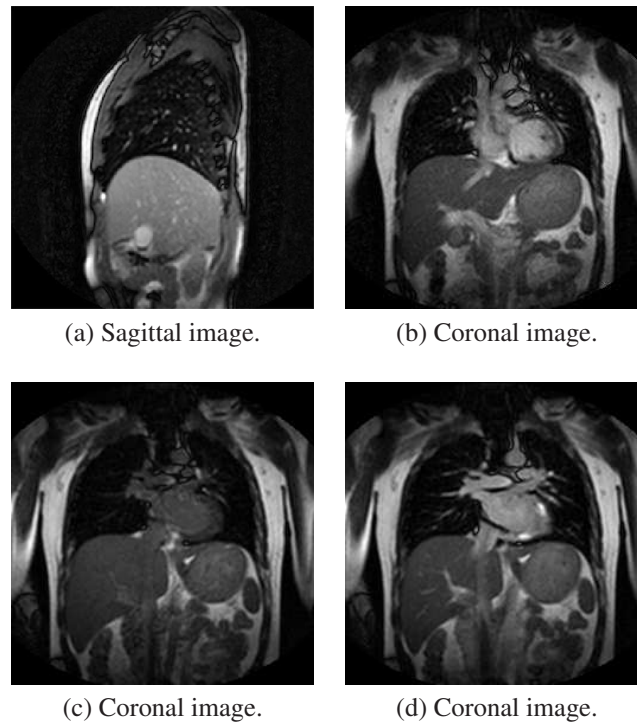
Samples of MR images. (a) shows a sagittal image. (b) shows the ascending aorta. (c) and (d) show different instants in time of the same slice.
